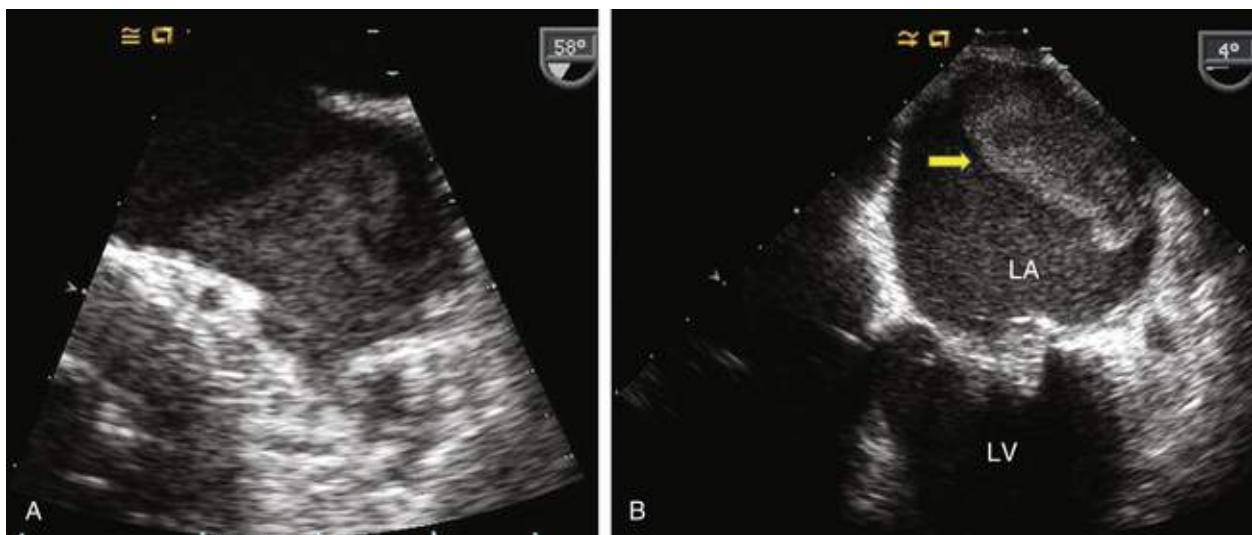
Spontaneous echocardiographic contrast and left atrial appendage thrombus. A, Zoomed TEE view of spontaneous echocardiographic contrast in the left atrial appendage in a patient with a bileaflet mechanical mitral prosthesis who was subtherapeutic with warfarin treatment. B, TEE view of organized thrombus (arrow) in the left atrial appendage in a patient following mitral annuloplasty. LA, Left atrium; LV, left ventricle. (See [Videos 14.53](#) and [14.54](#).)
